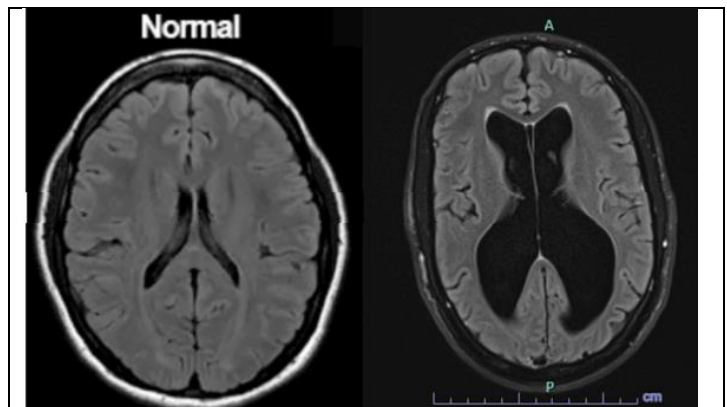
This patient's MRI shows extensive ventricular dilatation, resulting in normal pressure hydrocephalus, in contrast to normal ventricular size.
